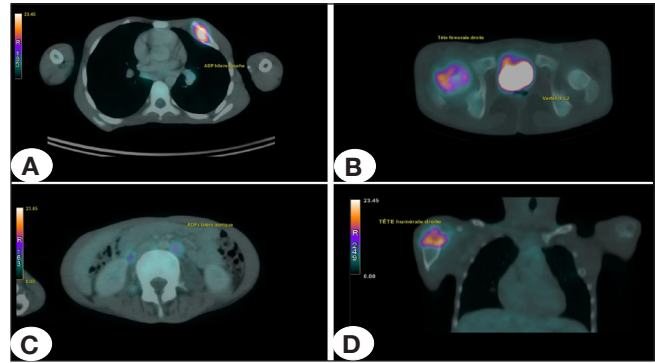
PET/CT images (Coronal and Transaxial) displaying intensely hypermetabolic osteolytic lesions in the right femoral head and L1 vertebral body.
